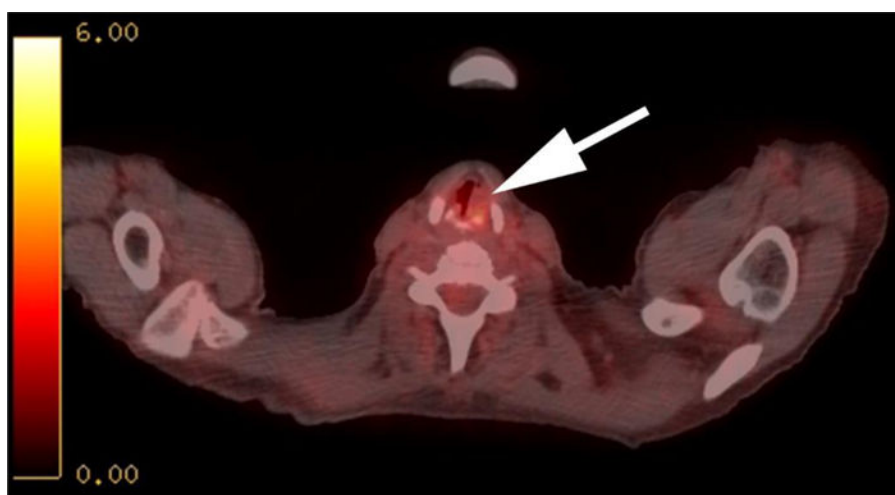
PET-CT scan displaying narrowed glottis and left vocal cord (white arrow) with increased fluorodeoxyglucose (FDG) uptake consistent with inflammation and hematoma.
